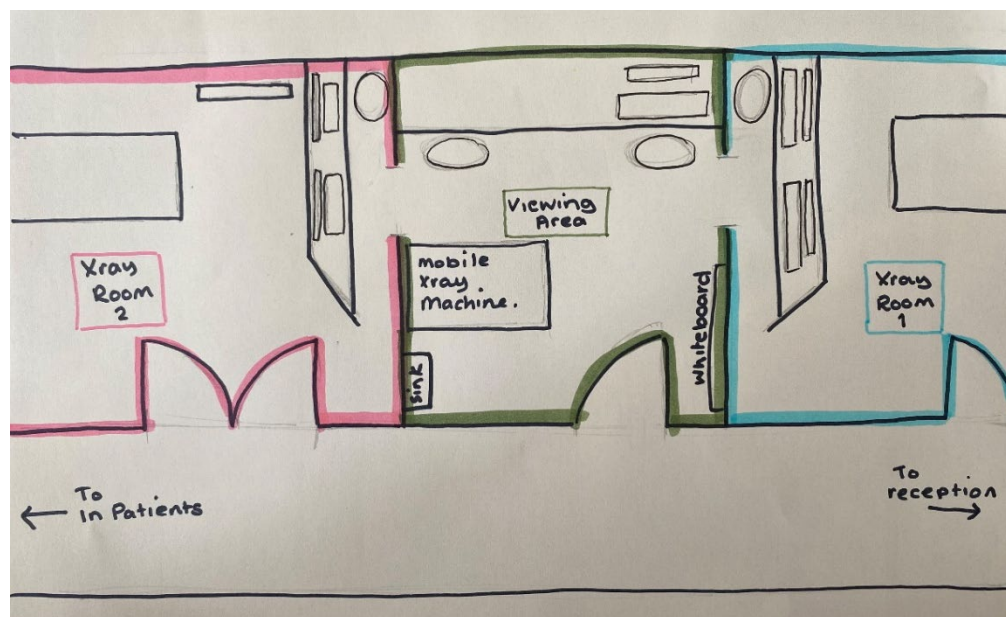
ED X-ray department floor plan
